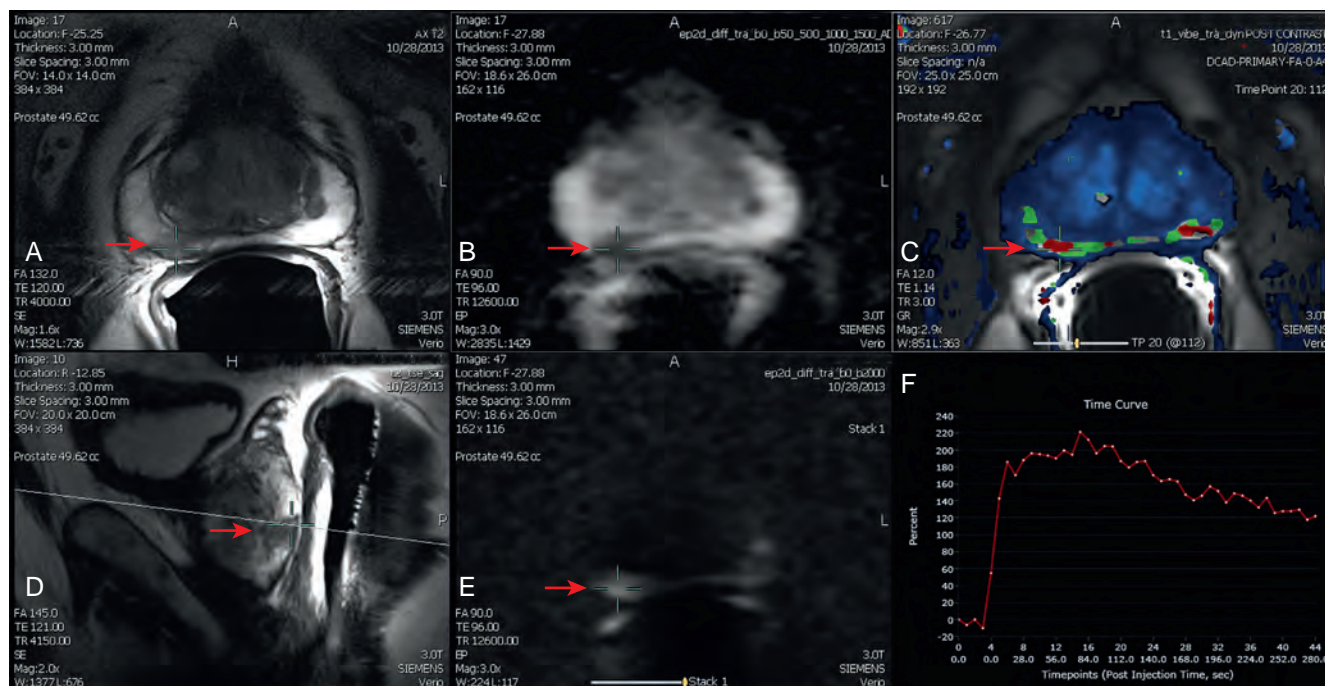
A 61-year-old Caucasian man with an increasing prostate-specific antigen (4.65 ng/mL) after a prior negative biopsy 1 year ago. Three-tesla multiparametric magnetic resonance imaging (MP-MRI) of the prostate with an endorectal coil was obtained. A, T2-weighted image with a homogeneous low signal intensity (SI) lesion within the right posterior peripheral zone (red arrow). B, Apparent diffusion coefficient (ADC) map with a corresponding low SI to the T2 sequence. C, Dynamic contrast enhanced MRI (DCE-MRI) with color mapping exhibiting a focal type 3 enhancement curve. D, Sagittal T2 sequence with a low-signal lesion within the peripheral zone. E, B-2000 diffusion-weighted imaging with high signal corresponding to T2, ADC, DCE abnormalities. F, Type 3 enhancement curve. The pathology was Gleason 3+4 prostate cancer, zone 3L, volume 0.3 mL (9 mm × 8 mm × 9 mm).
